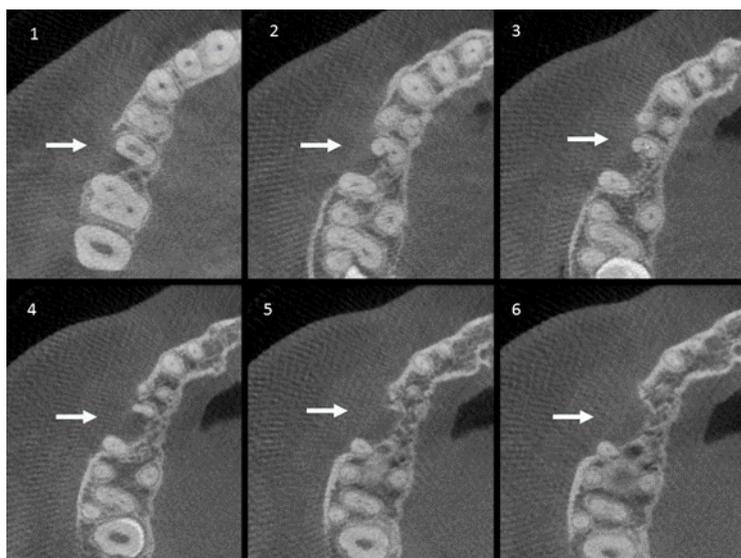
Axial CBCT images from coronal to apical show destruction of the cortex and cancellous bone.
